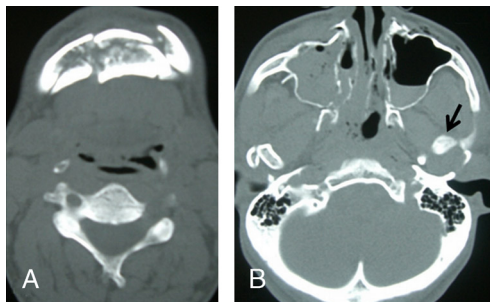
A and B, Face CT scan showing a left TMJ dislocation (arrow), Le Fort I fractures, and a mandibular body fracture.
